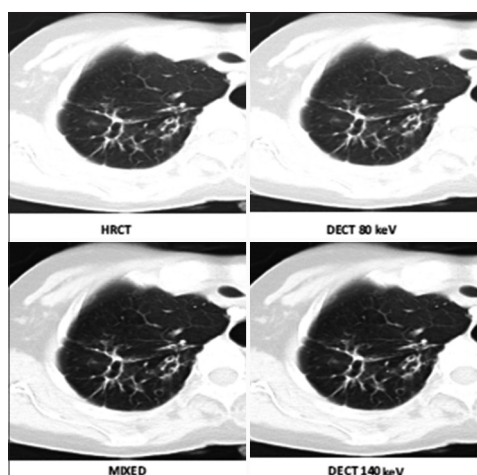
A 65-year-old woman who presented with fever cough and fatigue with diagnosis of pulmonary tuberculosis. Axial high-resolution computed tomography (CT) and contrast-enhanced dual-energy CT images showing bronchiectasis with peribronchial thickening. A calcified lymph node is noted in the right paratracheal region.
